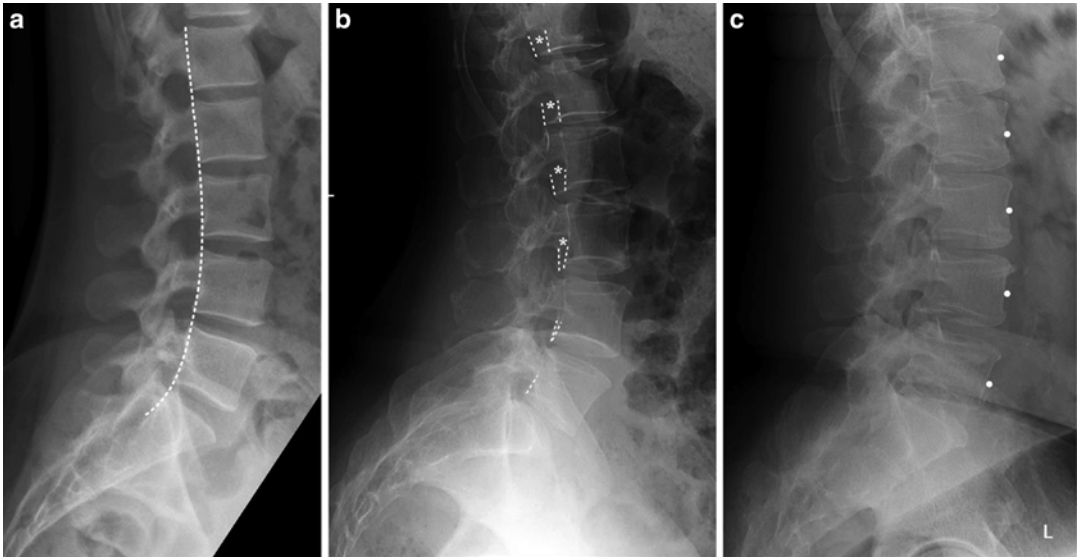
Assessment of vertebral body alignment on lateral radiographs with and without patient rotation. There is normal alignment in the examples shown. (a) Lateral lumbosacral spine radiograph with optimal positioning. A smooth, uninterrupted line is drawn along the posterior vertebral body margins of L1–S1 (*dashed line*). (b) Lateral view with patient rotation. The posterior vertebral margin of L5 is demarcated with a *single dashed line*.
